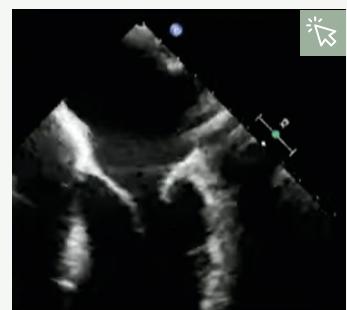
Baseline transthoracic (left) and transoesophageal (right) echocardiograms, displaying tethered leaflets.²⁷
